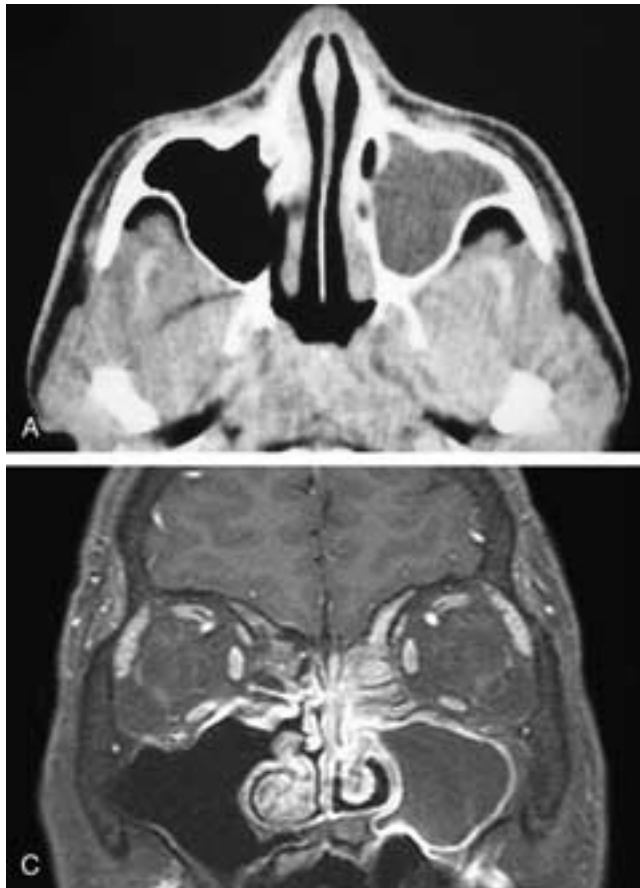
Axial CT scan (A) shows an opacified, obstructed left maxillary sinus. The sinus contents have an attenuation of water. Axial (B) and coronal (C) T1-weighted, fat-suppressed, contrast-enhanced MR images show an obstructed left maxillary sinus. The sinus mucosa enhanced about the secretions. There is also inflammatory disease in the left ethmoid sinuses.
